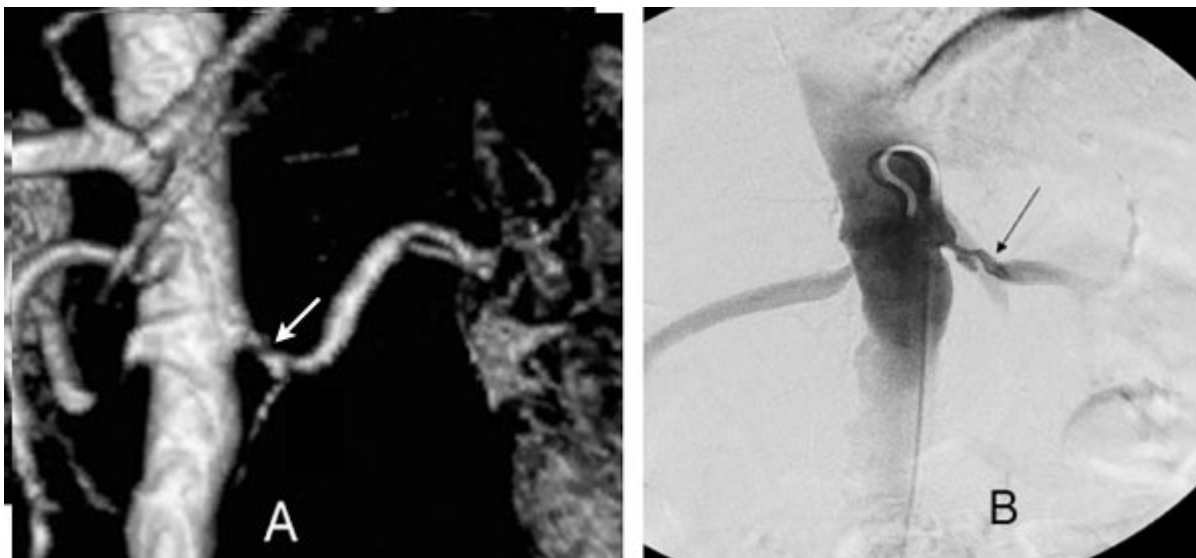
(A) MRA left renal artery stenosis (arrow). (B) Corresponding X-ray angiogram shows left renal artery stenosis (RAS) (arrow).
